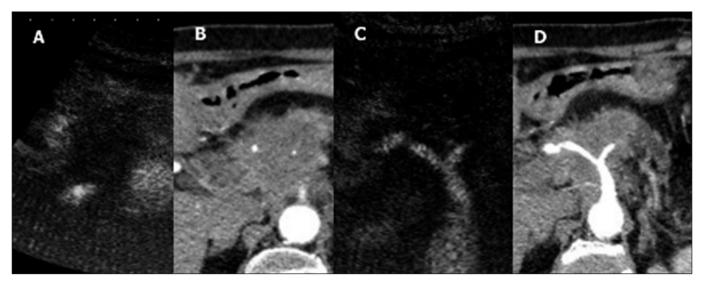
Comparison of ultrasound and CT imaging. The figure shows a pancreatic mass without enhancing in CEUS (A) that is compatible with pancreatic adenocarcinoma. CT shows a hypodense mass (B). Also, the figure shows celiac trunk and invasion of hepatic artery in CEUS (C) and CT (D).
